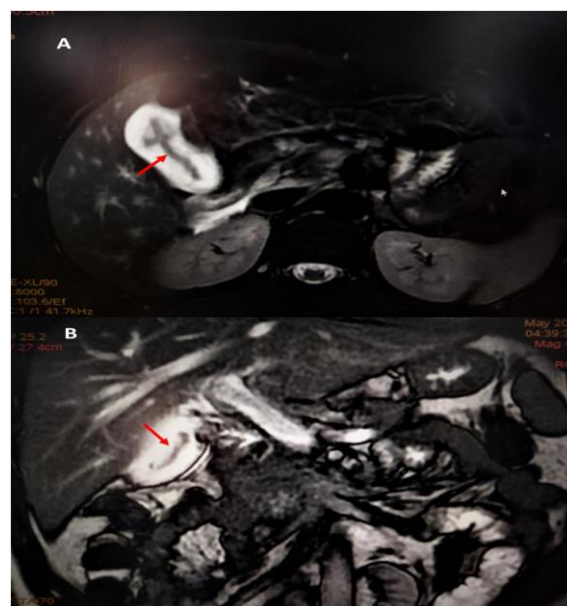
(A, B): T2-weighted axial magnetic resonance image showing a hypointense linear band and *Christ sign* in the Gallbladder (Arrow)
